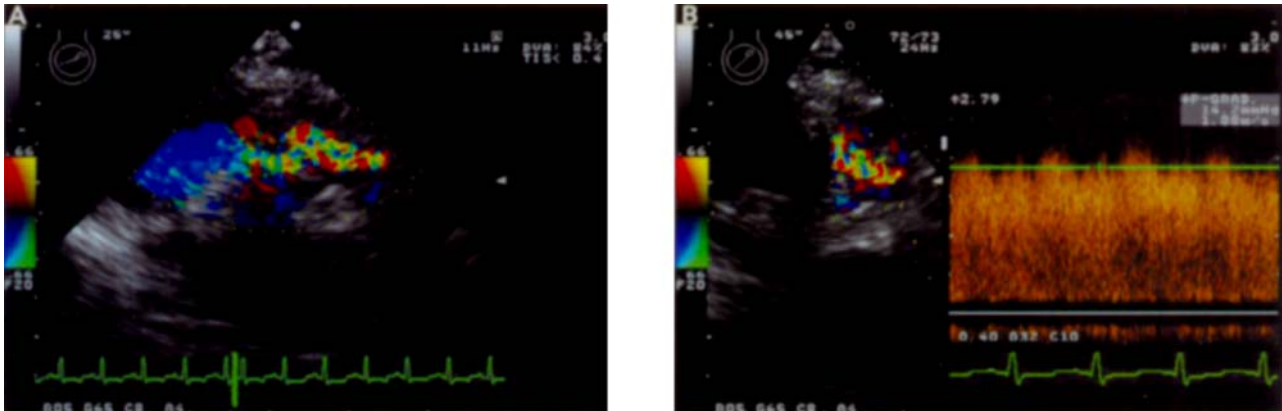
Anastomosis of left upper pulmonary vein after lung transplantation showing distortion and flow diversion in an S configuration, with a turbulent flow profile on (A) colour flow Doppler, which is indicative of stenosis. (B) Pulsed wave Doppler shows continuous flow of increased velocity without the characteristic pulmonary vein flow pattern. The calculated pressure gradient across the stenosis is 14 mmHg.
